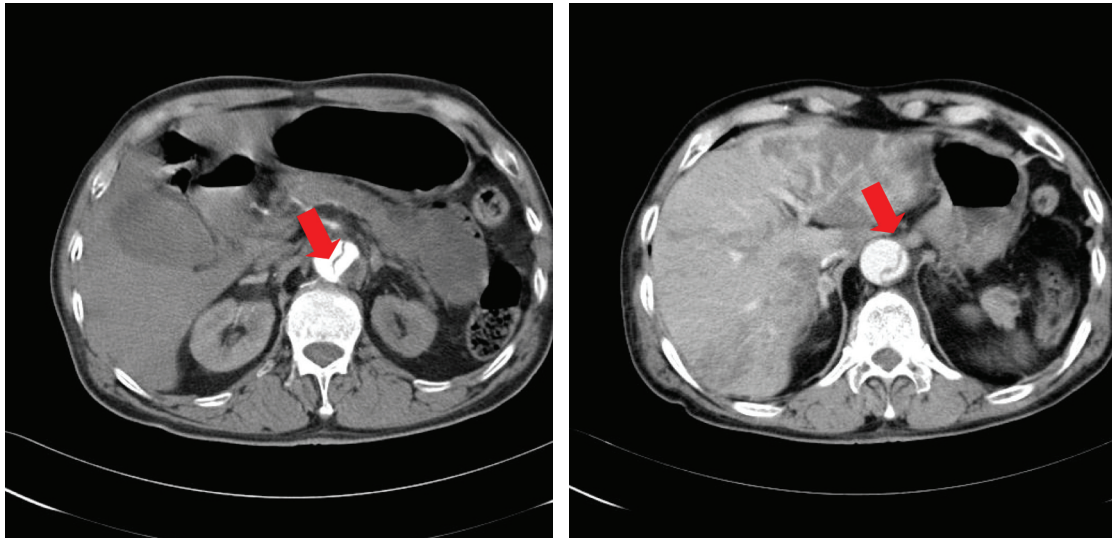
A. An abdominal CT scan showed aortic dissection extending from descending thoracic aorta to entire intra-abdominal aorta, occlusion of celiac axis is noted.
